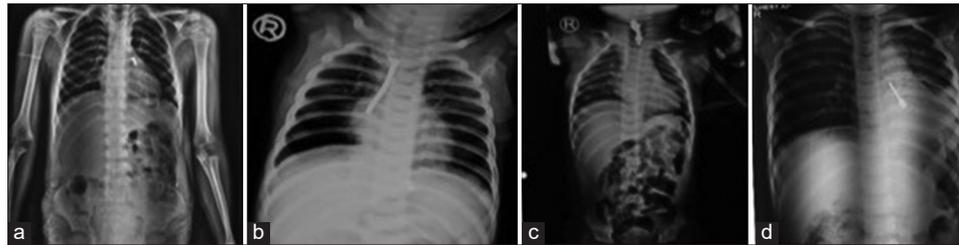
X-ray chest of foreign body aspiration cases; (a) screw in the left bronchus; (b) nail in the right bronchus; (c) earring in laryngopharynx; (d) charger pin in the left bronchus
